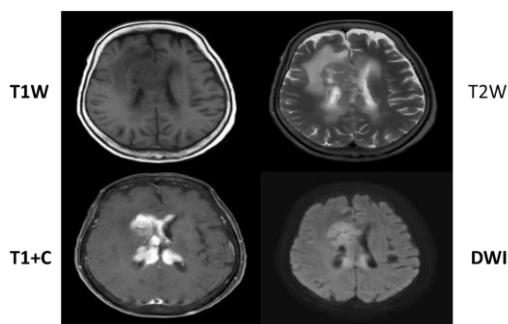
An axial T1W and T2 weighted MR images shows the genu and splenial lesion appearing isointense with respect to gray matter. An axial T1W+C MR image after contrast shows periventricular nodular homogenous intense enhancement. DWI demonstrates high signal intensity
